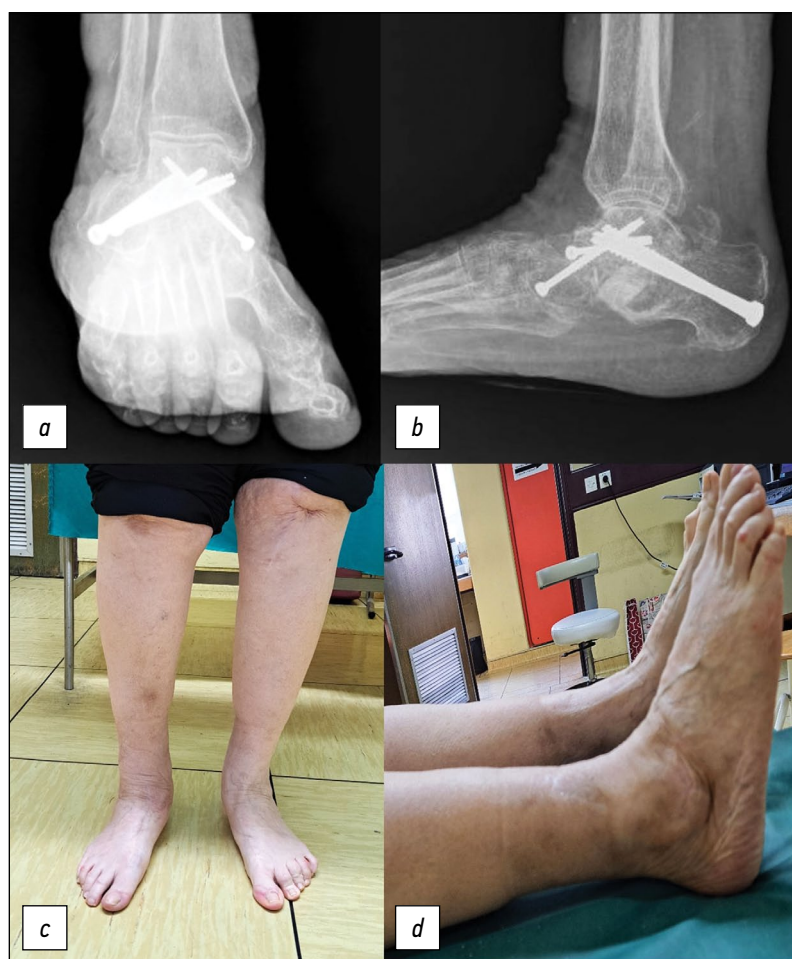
Plain radiographs and clinical images six months following the procedure: anteroposterior (*a* and *c*) and lateral (*b* and *d*) views.
